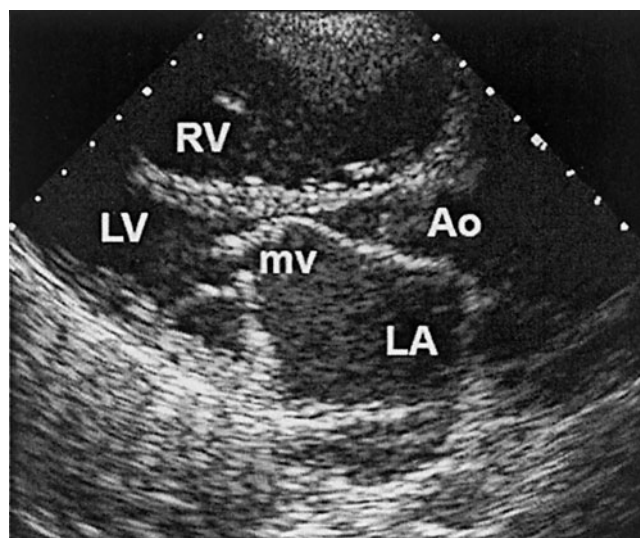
Parasternal long-axis view of a patient with mitral stenosis. Note the thickening and hockey-stick deformation of the anterior leaflet of the mitral valve (mv) and the protrusion of the posterior leaflet. Note also the normal left ventricle (LV) contrasting with the enlarged left atrium (LA) and right ventricle (RV). Ao = aorta.
